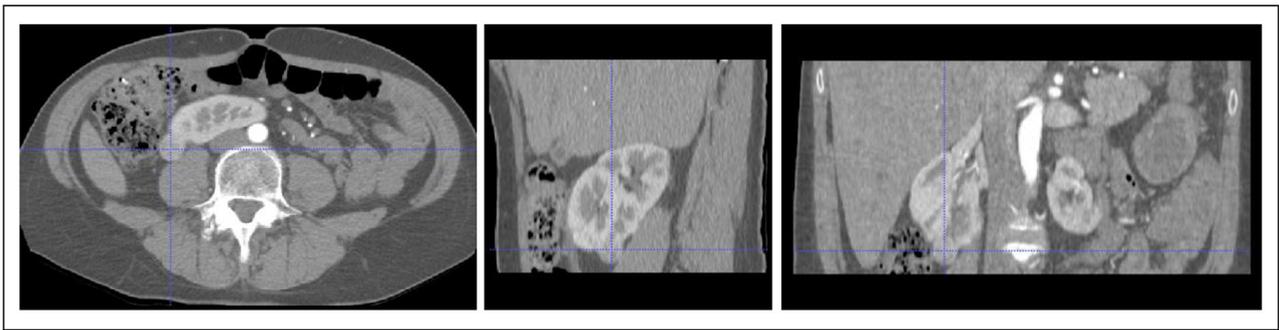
Cross-sectional contrast-enhanced CT axial, sagittal, and coronal images acquired at the arterial phase. Tumor location in each image is indicated by the blue crosshair.
